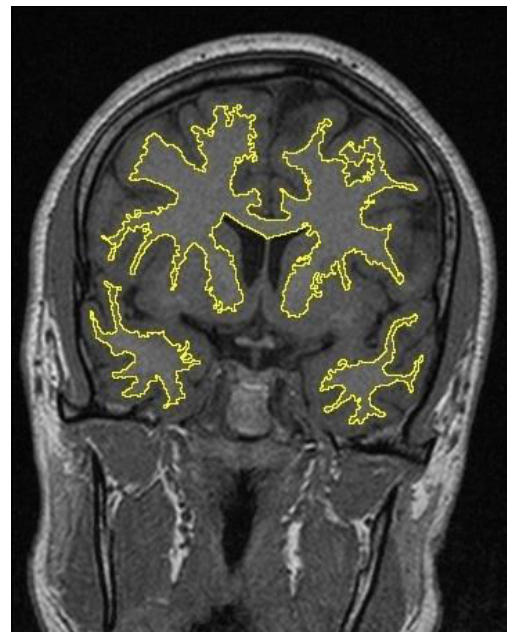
A coronal MR image of the brain. Application of the selection tool for white mater.
